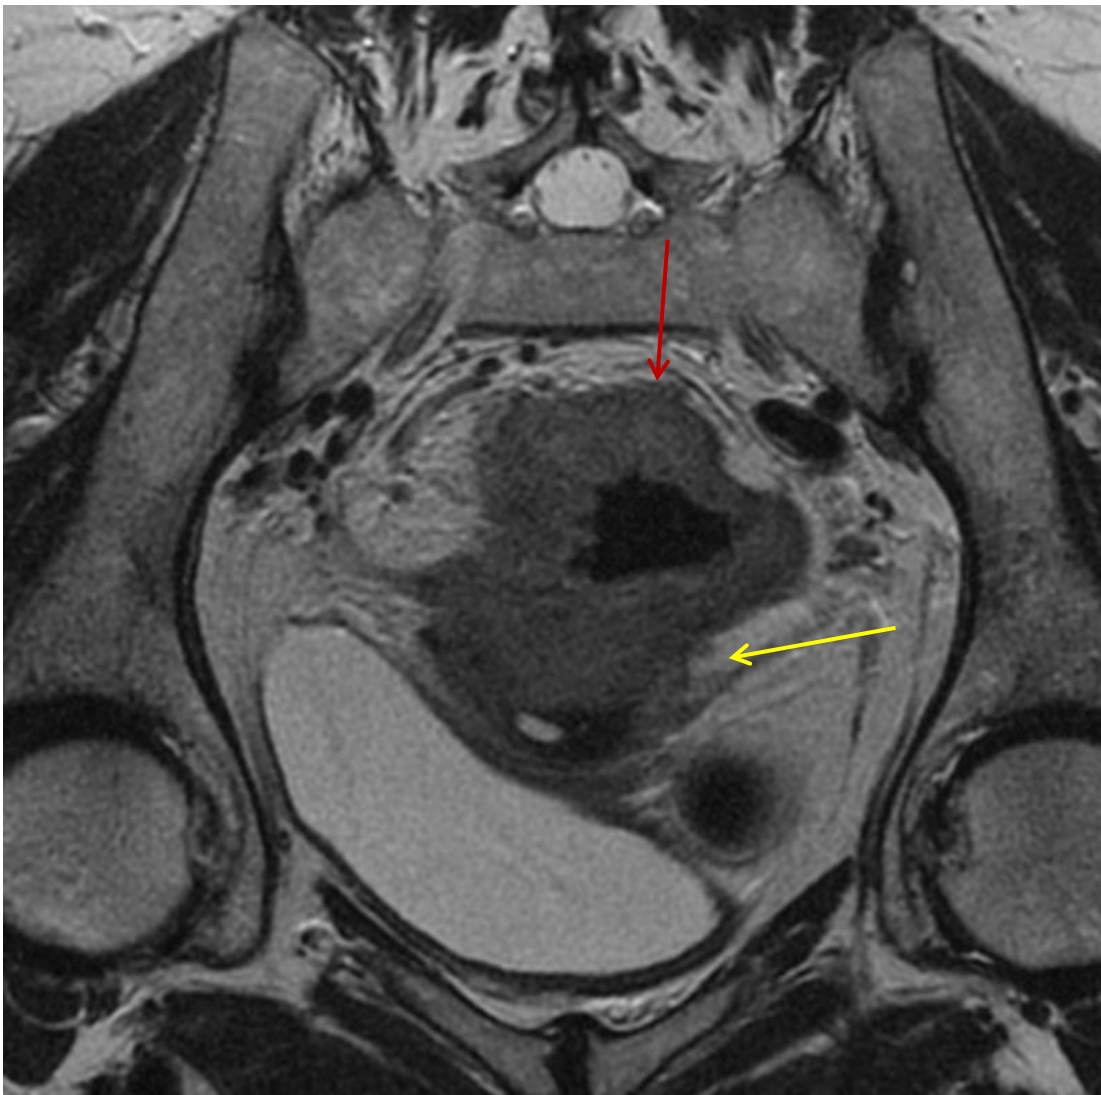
(Case 139) Coronal MRI images of a 59-year old female patient with a locally advanced voluminous mucinous upper rectal cancer (shown by red arrows) staged cT4N1b with invasion of the uterus and collapse of the endometrial lumen (infiltration shown by the yellow arrows)
